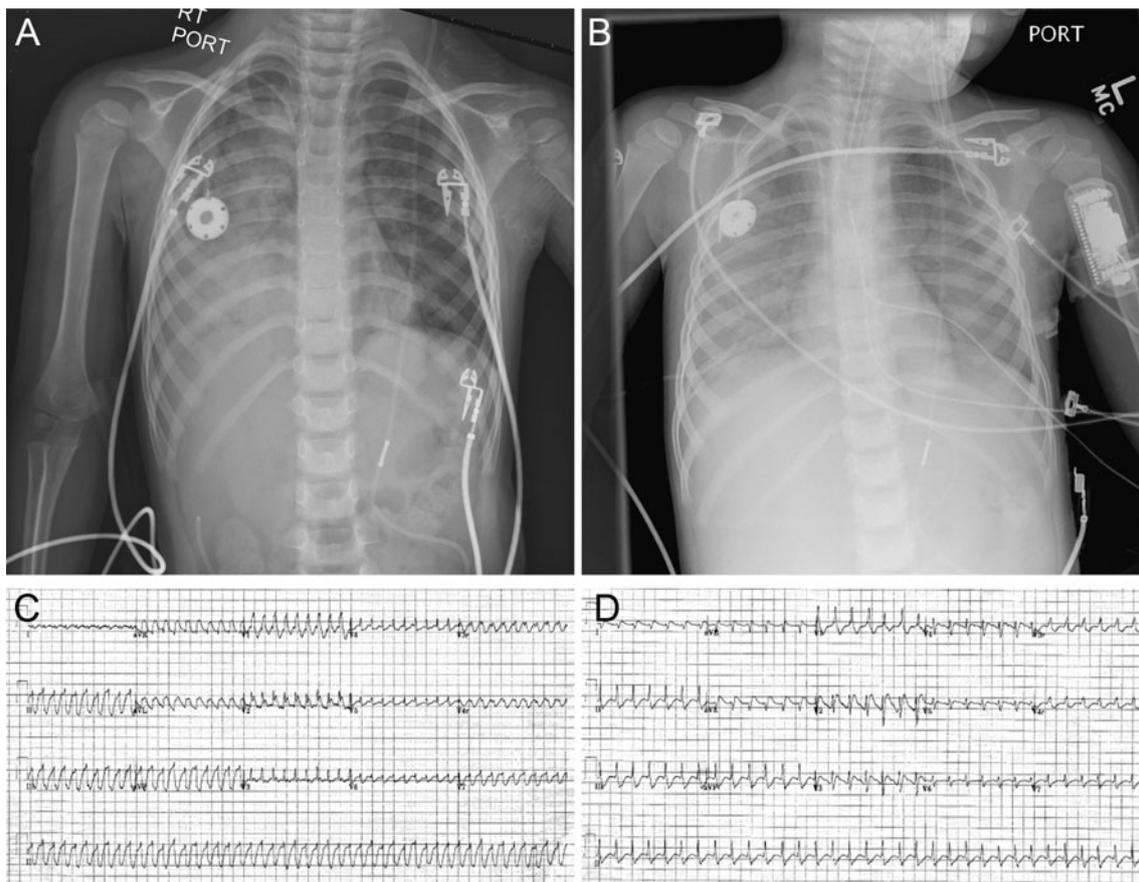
Significant cardiopulmonary images from the time of the decompensation. a Representative chest X-ray demonstrating right chest opacification. b Representative chest X-ray demonstrating
